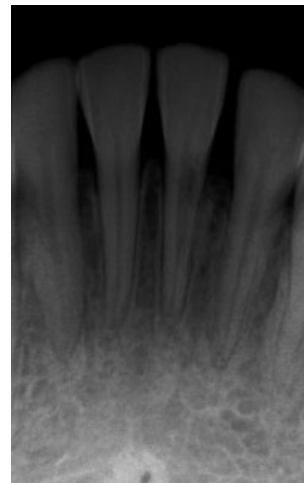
Radiograph taken 10 months after trauma. Advanced resorption in the lower left first incisor is evident.
